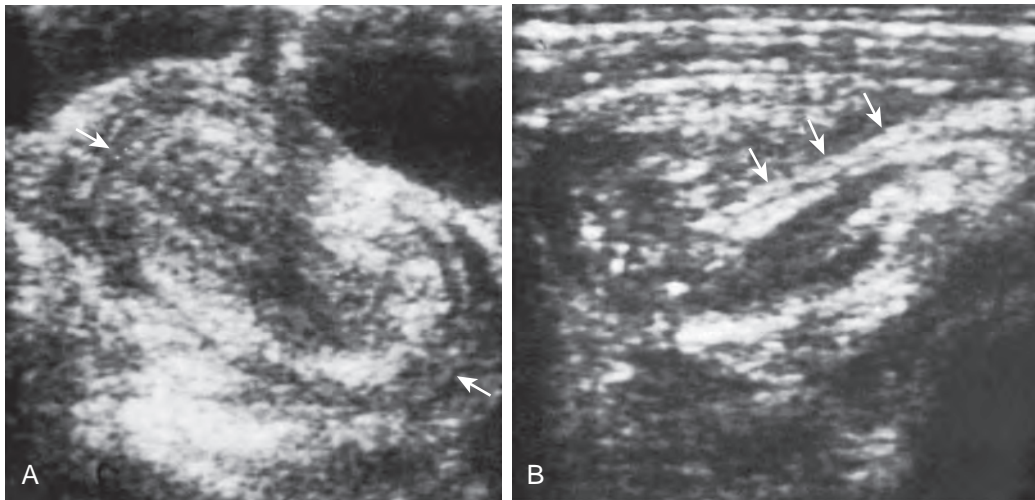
Sonography of intussusception. A. The target (arrows) appearance of intussusception is demonstrated on this longitudinal sonogram. The hypoechoic structures anteriorly are dilated bowel loops. B. Transverse scan of a different patient shows the parallel echogenic mucosa (arrows) of the intussusciens and intussusceptum.
